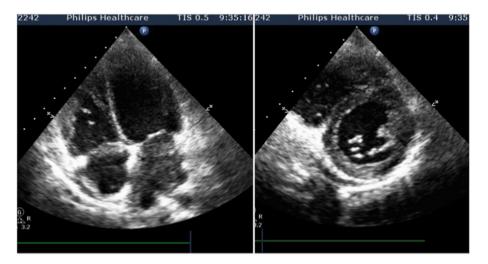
Echocardiography demonstrating heart profile enlargement with mild pericardial effusion.
